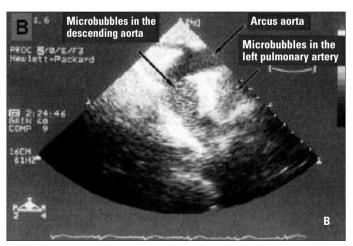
Contrast echocardiographic images in a patient with patent ductus arteriosus with right-to-left shunt from suprasternal long axis view. A, Before contrast. B, During contrast injection, the passage of microbubbles from patent ductus arteriosus results in opacification of the descending aorta, however, ascending aorta is not opacified.
